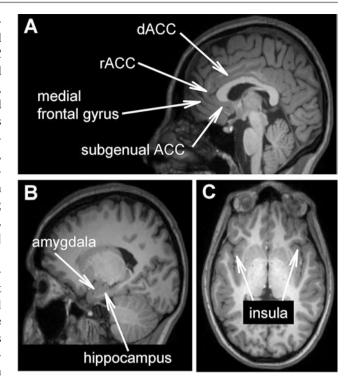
Structural magnetic resonance images (MRIs) showing the structures of interest in this chapter: (a) a sagittal MRI slice showing the dorsal anterior cingulate gyrus (dACC) and structures comprising the ventral medial prefrontal cortex (vmPFC) including the rostral anterior cingulate cortex (rACC), medial frontal gyrus, and subgenual ACC; (b) a sagittal slice showing the amygdala and hippocampus; and (c) a horizontal slice showing bilateral insula (also called the insular cortex)
